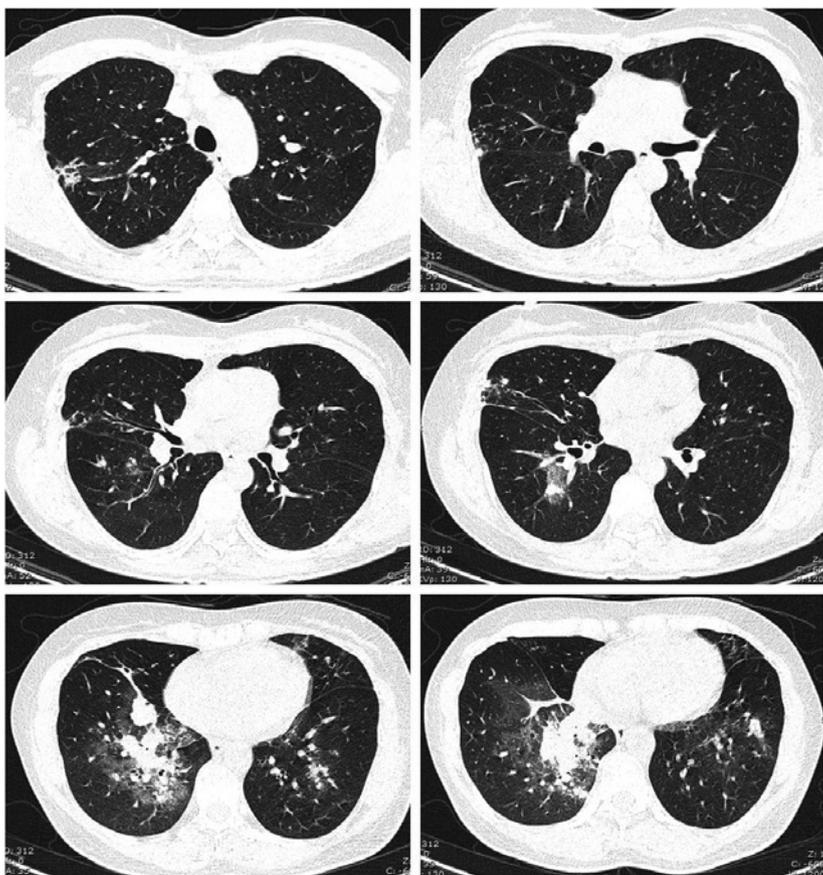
CT scan of the thorax at initial presentation.
